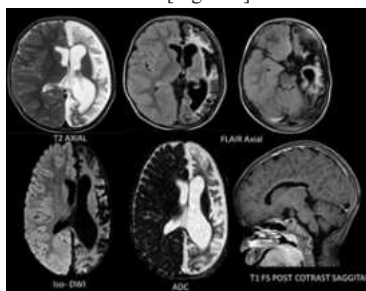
Case of an 8-year-old male patient with Rasmussen's Encephalitis, Axial T2 and FLAIR sections reveal significant diffuse atrophy throughout the left cerebral hemisphere, affecting the cortex, white matter, and deep grey matter, associated with encephalomalacia, marked gliotic changes, and subcortical cystic alterations in the frontal and parieto-occipital lobes with patchy areas of cortical diffusion restriction. Wallerian degeneration in the left hemi-midbrain, along with diffuse thinning of the corpus callosum.
